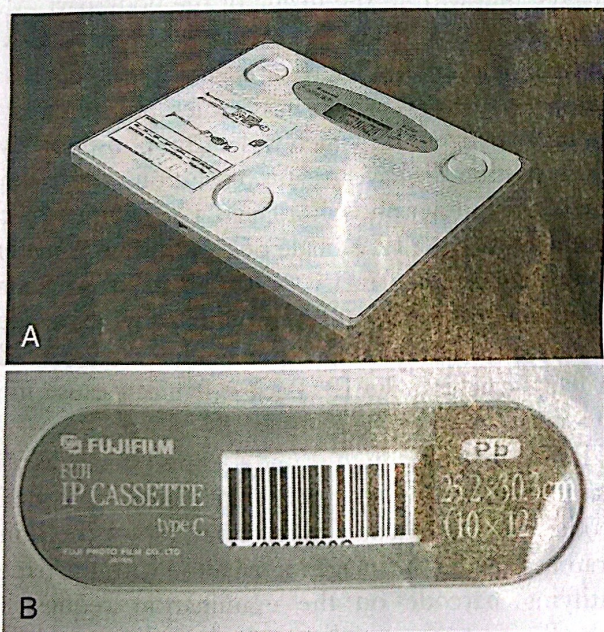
(A) Conventional computed radiography (CR) imaging plate (IP). The plate contains a storage phosphor that stores the x-ray energy. (B) Barcode label on the CR cassette allows matching of the image with the correct patient.
